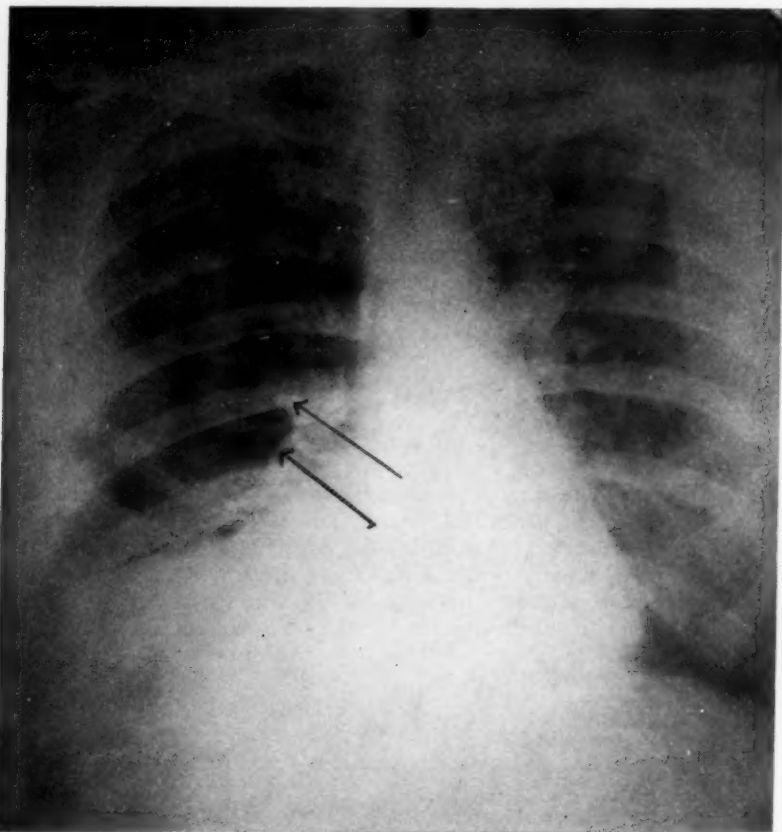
October 5, 1937. (Dr. Fred Hodges, Richmond, Virginia, Roentgenologist.) Note two rounded masses in the right hilar zone and the apparent elevation of the right diaphragm, with decreasing density of the shadow from the midclavicular line to the periphery.
